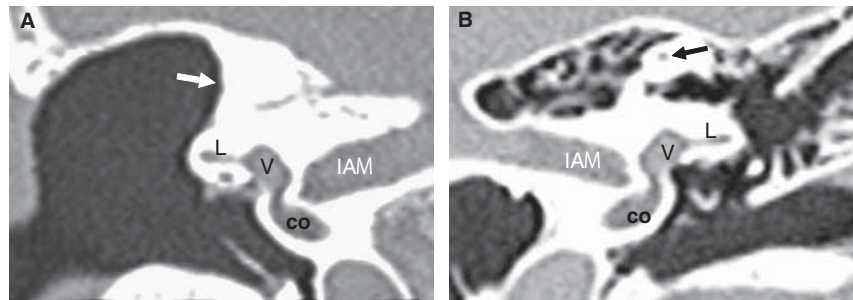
Case 1. CT scans of the middle ear 13 years after the surgery showing the right ear (operated) with the superior semicircular canal (SSCC) removed (A, white arrow), and left ear (normal) with the intact SSCC (B, black arrow). co, cochlea; IAM, internal auditory meatus; L, lateral semicircular canal; V, vestibule.
